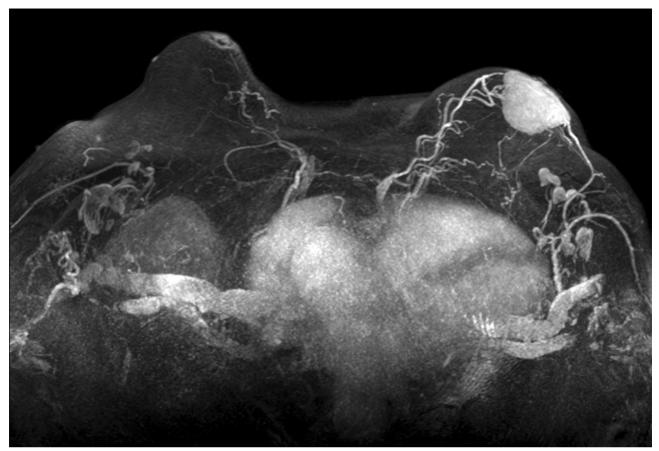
Breast MRI, axial maximum intensity projections (MIP). Axial MIP demonstrated a mass enhancement on T1W FS after IV gadolinium administration.
